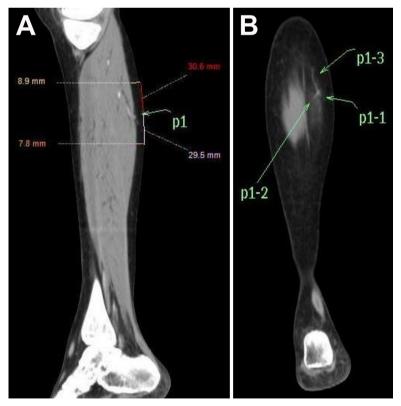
Computed tomography angiogram showing the medial sural artery perforator. (A) The perforator (green arrow) emerging from the medial gastrocnemius muscle is marked on the sagittal plane. (B) Three branches of the first perforator in the subcutaneous tissue are marked on the coronal plane.
